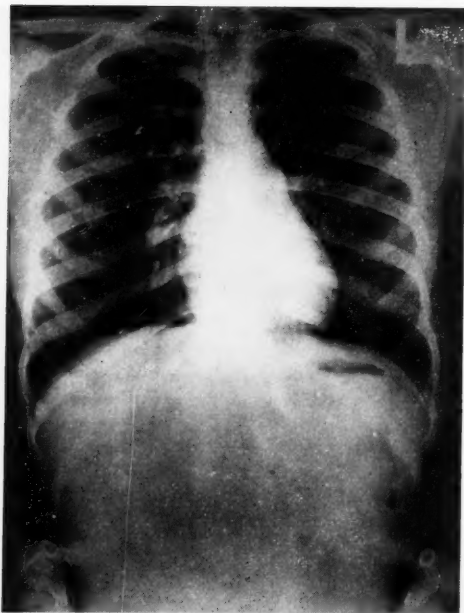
X-ray showing pin lying in patient's right lung.
